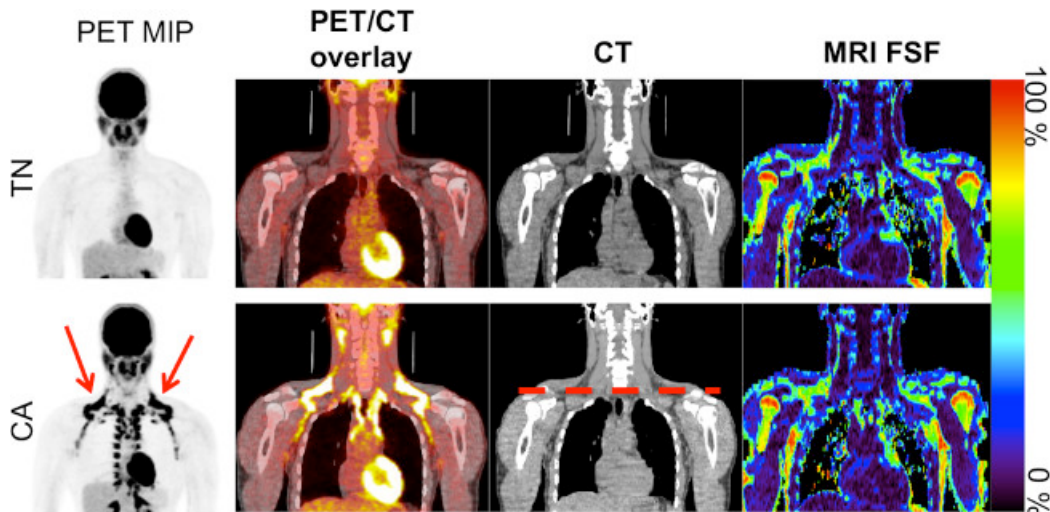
Coronal images from the warm (TN) and cold (CA) scans for one subject showing the PET maximum intensity projection (MIP) in inverse gray scale, PET/CT overlay, CT, and MRI fat signal fraction (FSF). Note the increased ^{18}F -FDG uptake in the clavicular region (red arrow), as well as down the spinal column on the CA PET MIP scan, indicating activated brown adipose tissue. The dashed red line on the CA CT image indicates the clavicular region to be further analyzed. [Please click here to view a larger version of this figure.](#)
